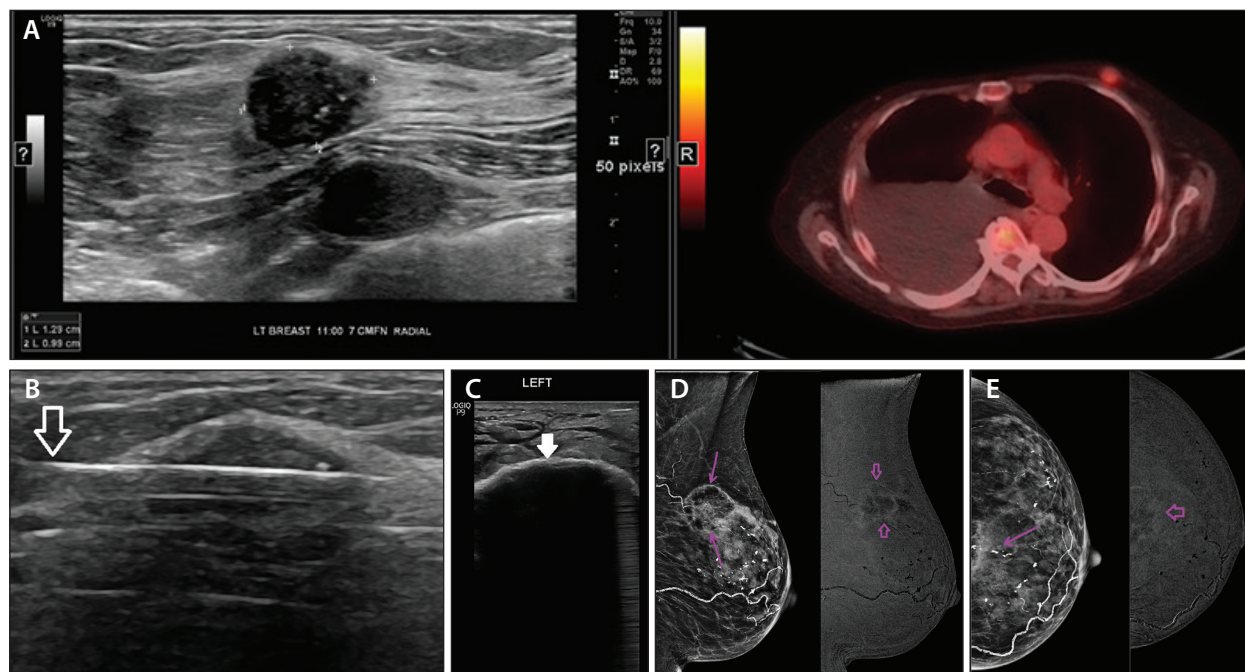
Ultrasound of the biopsy-proven breast cancer and the positron emission tomography (PET)/CT performed for concomitant cancer in this patient with comorbidities demonstrates a PET-avid breast mass (A). Ultrasound image of the cryoablation probe within the tumor (B). Ultrasound image demonstrates a shadowing ice ball (solid white arrow) (C). Contrast-enhanced mammogram in the mediolateral oblique view demonstrates a routine view with the ablation zone (purple arrows) and without enhancement within the ablation zone (open purple arrows) (D). Contrast-enhanced mammogram in the craniocaudal view demonstrates a routine view with ablation zone (purple arrows) and without enhancement within the ablation zone (open purple arrows).
